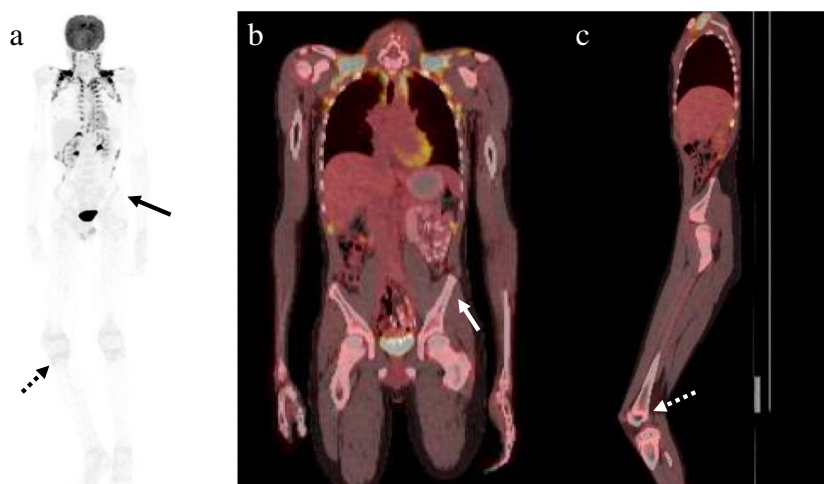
Staging FDG PET/CT for a 14-year-old boy with newly diagnosed primary lymphoma of bone in the right proximal tibial epiphysis. Coronal MIP (a) and coronal CT fused (b) images showing FDG avidity in the left iliac wing (solid black and white arrows, respectively), corresponding to the indeterminate mixed lytic and sclerotic
